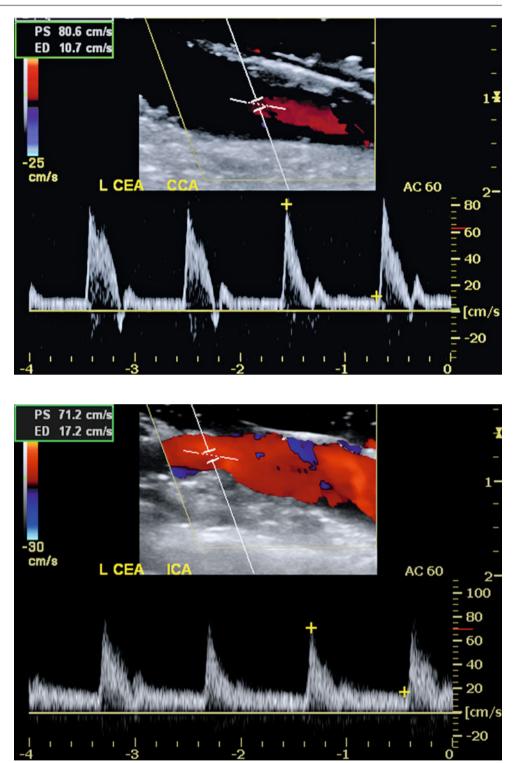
Duplex ultrasound image of vein patch endarterectomy site with normal color Doppler imaging and velocity spectra (mild spectral broadening, peak systolic velocity <150 cm/s)
